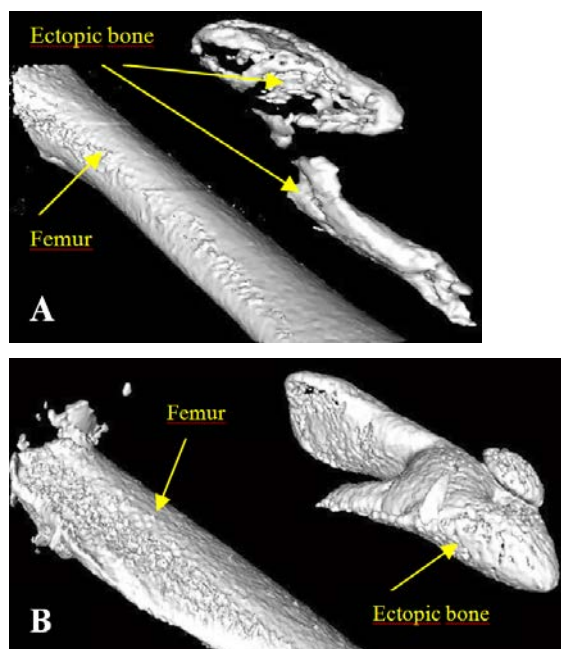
CT-scan surface rendering showing ectopic bone at 3 weeks induced by 150 μg rhBMP-2 in chitosan (A) and hyaluronic acid (B) hydrogels at pH 4.8
